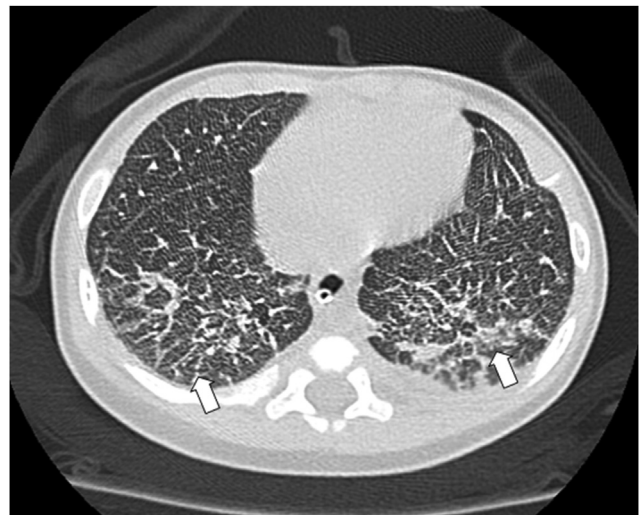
Thorax HRCT showing a diffuse ground glass appearance, particularly in both lower lobes, with thickened intralobular and interlobular septa suggestive of childhood interstitial lung disease.
